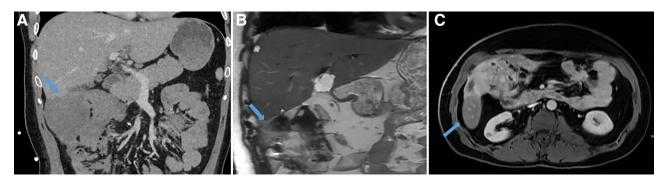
Desmoid encroachment on the liver. A, Coronal CT image. B, T2-weighted coronal MRI image. C, Axial MRI image following intravenous gadolinium demonstrating a desmoid mass abutting the capsule of segment 5/6 of the liver. This tumor was carefully resected off the liver to preserve it. CT, computed tomography.
